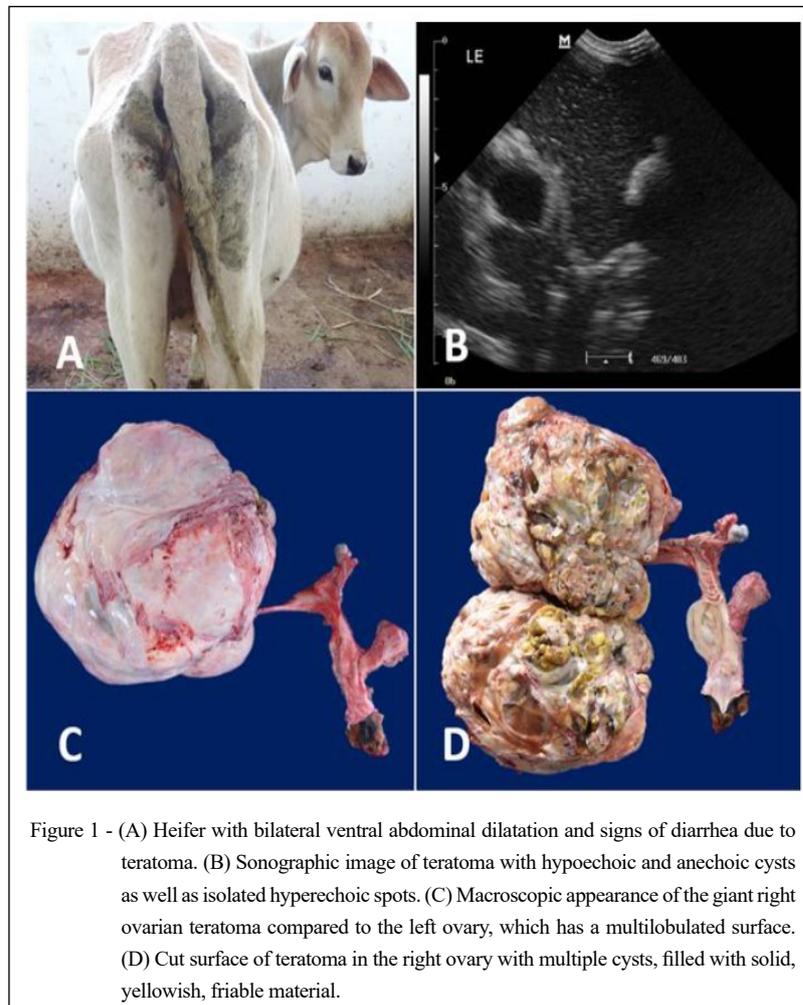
(A) Heifer with bilateral ventral abdominal dilatation and signs of diarrhea due to teratoma. (B) Sonographic image of teratoma with hypoechoic and anechoic cysts as well as isolated hyperechoic spots. (C) Macroscopic appearance of the giant right ovarian teratoma compared to the left ovary, which has a multilobulated surface. (D) Cut surface of teratoma in the right ovary with multiple cysts, filled with solid, yellowish, friable material.
